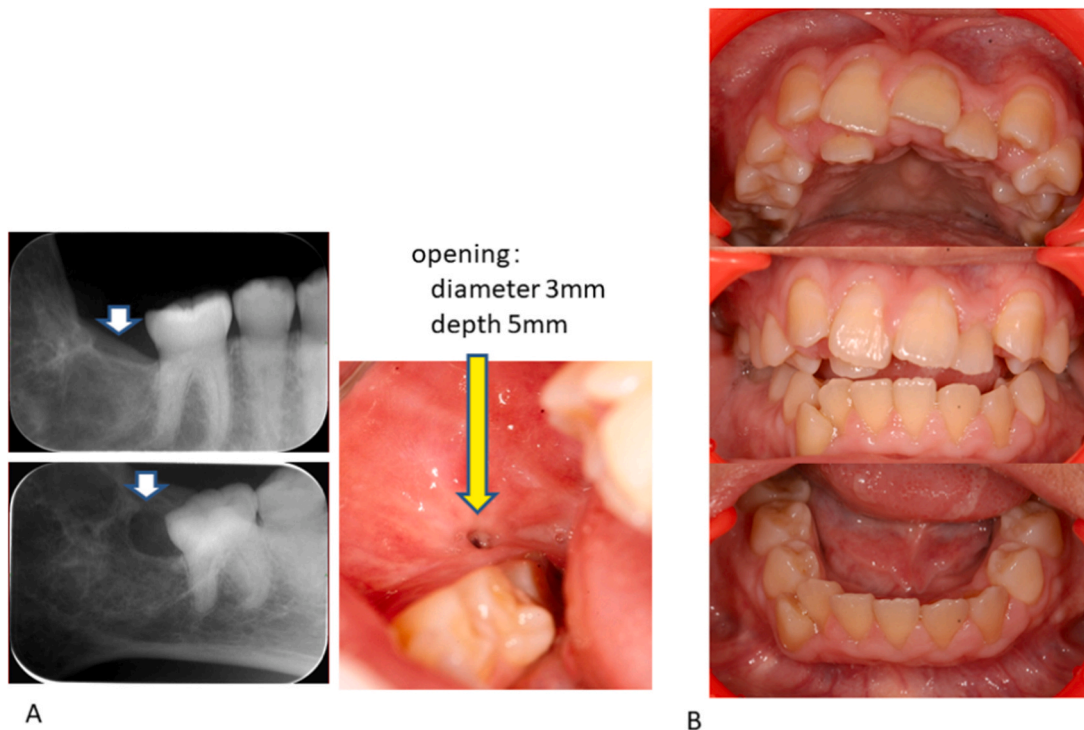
Dental X-ray photograph and the intraoral photograph. A dental X-ray and intraoral photograph of lower right second molar equivalency area. B intraoral photograph (22 year and 6 months old).
